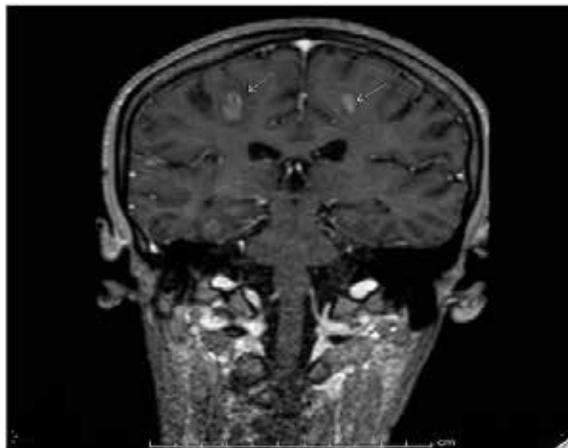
Cranial MRI image of the patient
